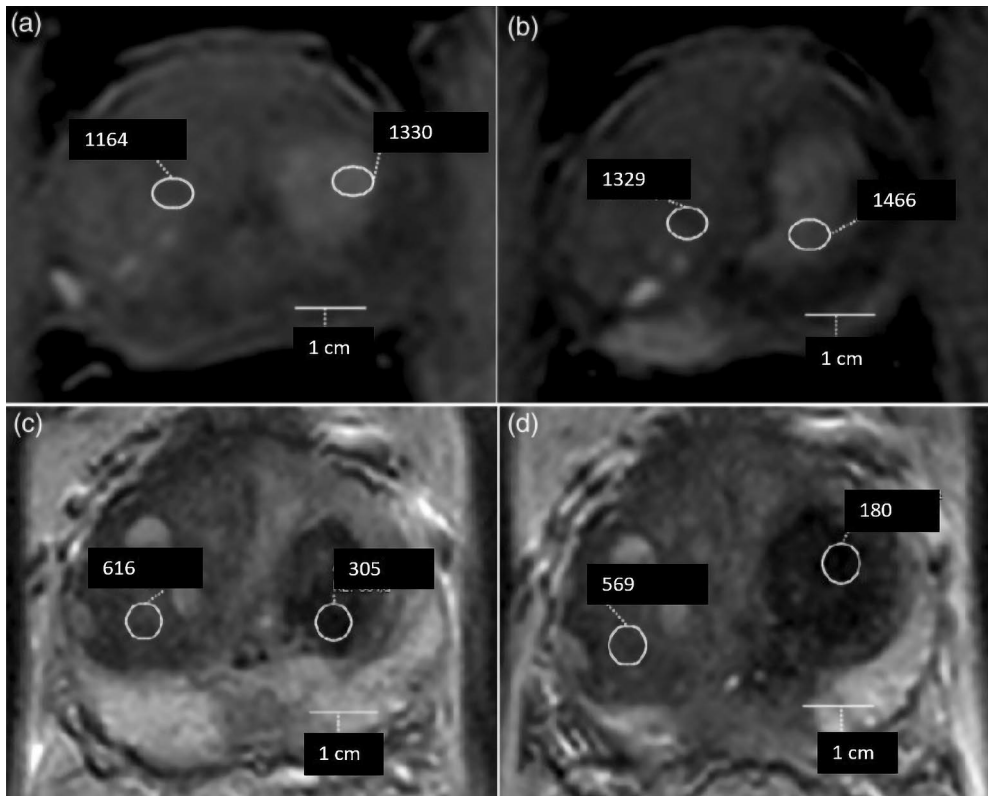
Example of T1 and T2 signal intensity measurements. The 1- and 3-week axial T1W fat-saturated non-contrast images (a, b), and the corresponding T2-weighted non-contrast images (c, d). (Modified from original publication I)
